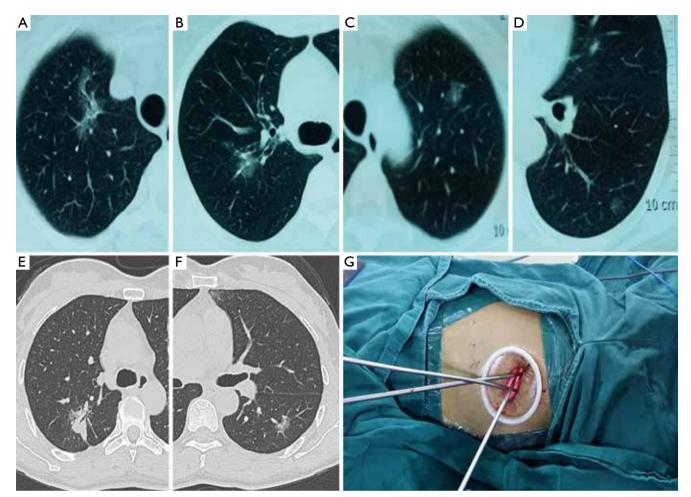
(A-D) High-resolution computed tomography (HRCT) reveals four ground glass opacity (GGO) lesions of patient 1 (a 3.2×1.5 cm lesion located at the apical segment of the right upper lobe, a 1.3×1.0 cm lesion located at the posterior segment of the right upper lobe, a 1.0×0.8 cm lesion located at the apical segment of the left upper lobe, and a 0.8×0.8 cm lesion located at the posterior basal segment of the left upper lobe, and a 0.8×0.8 cm lesion located at the posterior segment of the right upper lobe, and a 0.8×0.8 cm lesion located at the posterior segment of the right upper lobe, and a 0.8×0.8 cm lesion located at the posterior basal segment of the left lower lobe); (E,F) HRCT reveals two tumor-like lesions of patient 2 (a 3.0×2.5 cm mass located at the posterior segment of the right upper lobe and a 1.6×0.9 cm GGO lesion located at the superior segment of the left lower lobe); (G) surgical image of instrumentation during right upper lobectomy.
